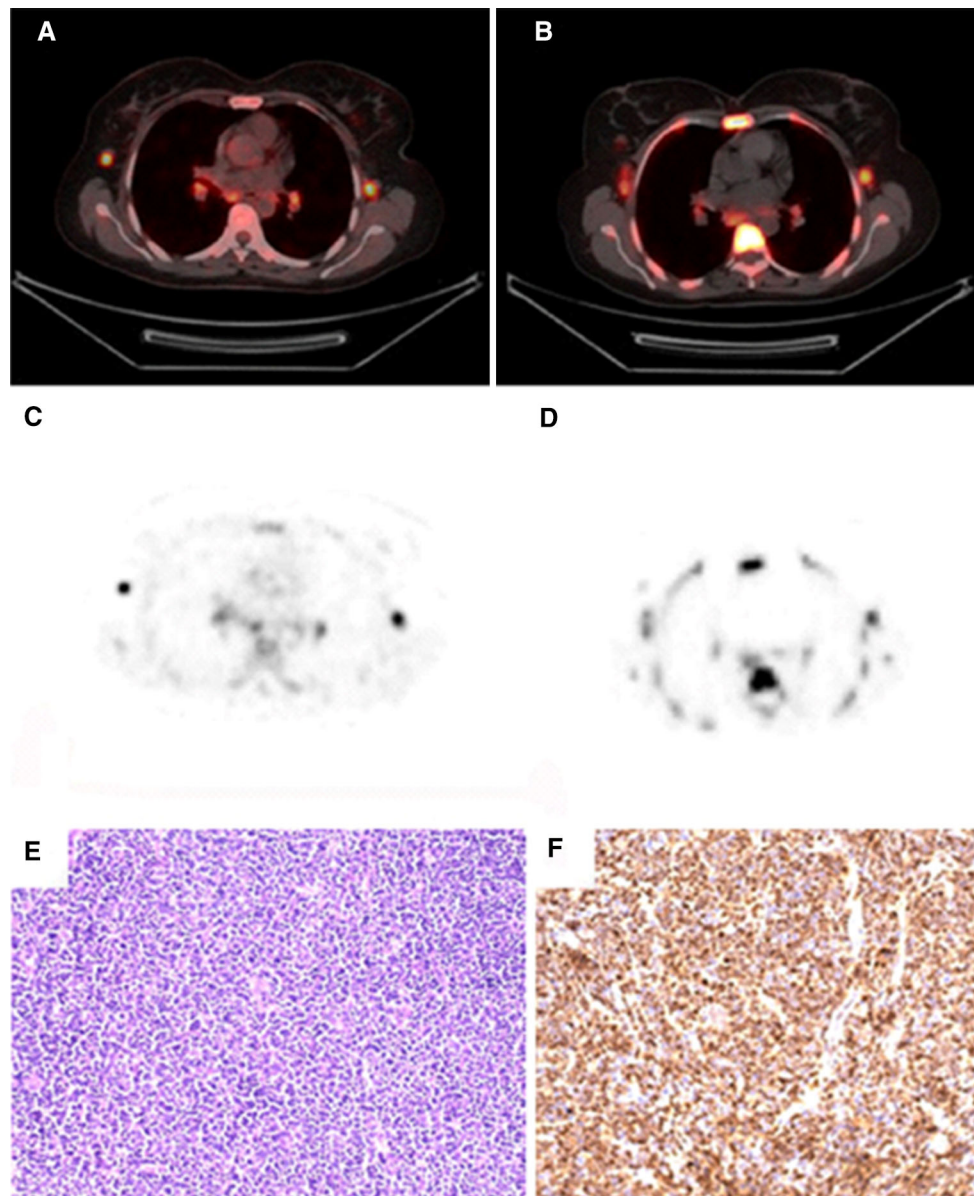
Transaxial fused ^{18}F -FDG PET/CT (a) and ^{18}F -FLT PET/CT (b), FDG PET only (c) and FLT PET only (d) showing increased tracer uptake in bilateral hilar lymph nodes in a Mantle cell lymphoma patient. Lymph node biopsy showing sheets of lymphoma
